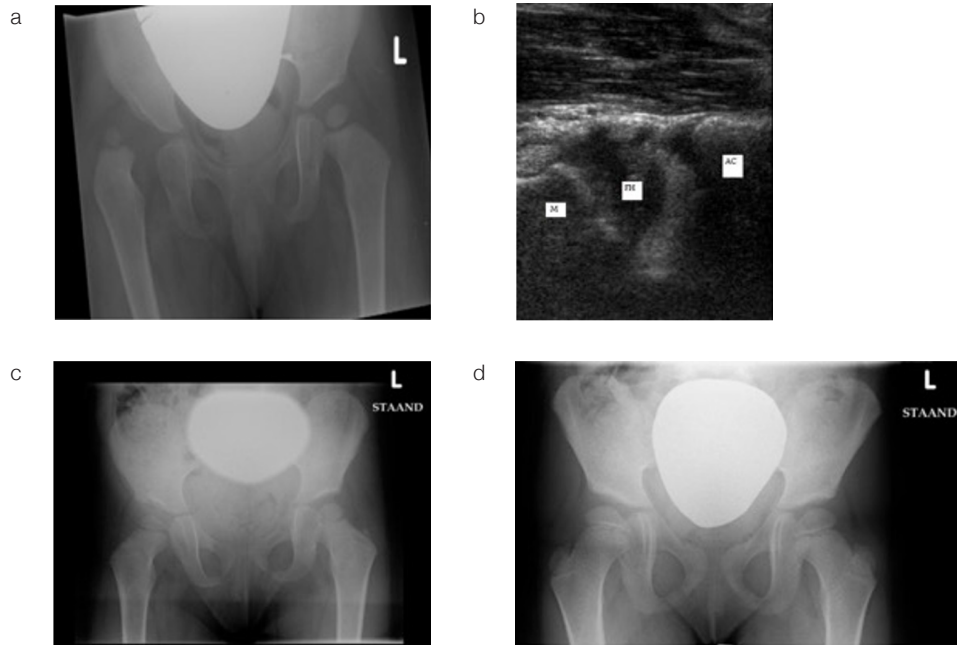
Patient 19: Successful Pavlik treatment in late-diagnosed dislocated right hip in a 23 months old girl. a. Pelvis X-rays at initial diagnosis (at 23 m). b. Transinguinal ultrasound to confirm the reposition of the right hip after 8 weeks of Pavlik treatment. (M= metaphysis, FH= Femoral head, AC = acetabulum). c. Pelvis X-rays at 1 y after reposition (at 2 y 1m) and d. final follow-up (at 5y3m).
